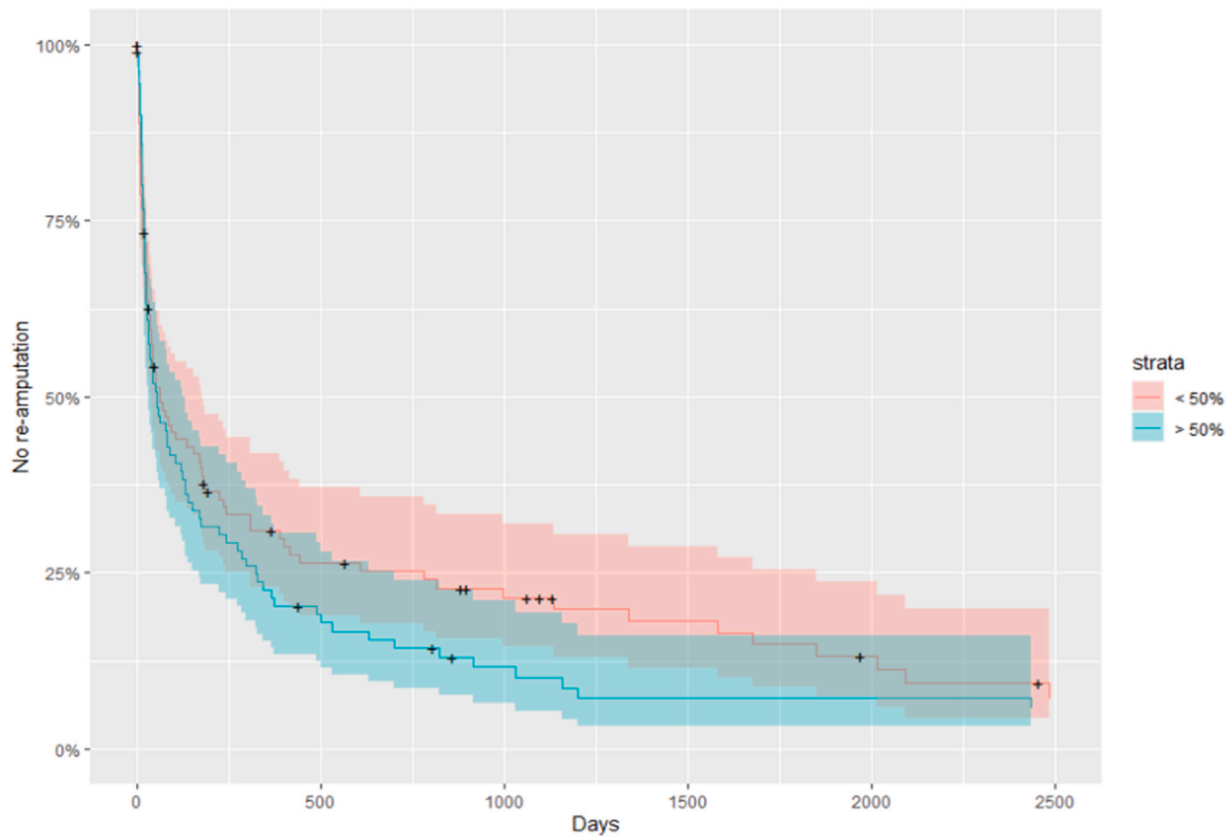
Kaplan Meier curve for survival between amputations percentage of stenosis in doppler ultrasound.
